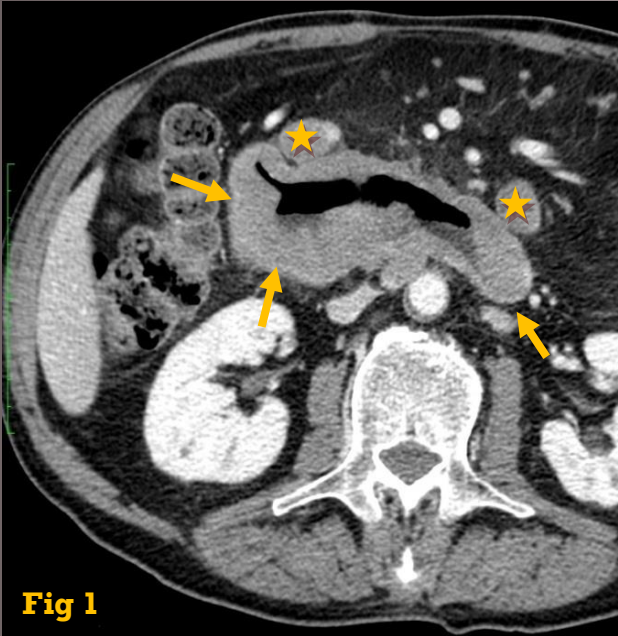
Contrast-enhanced CT shows homogeneous (with gray attenuation) and asymmetric thickening of the duodenal wall with mild dilatation of the lumen (arrows); there is biliary and Wirsung duct dilatation (arrowheads); perilesional adenopathies are also evident (stars).
